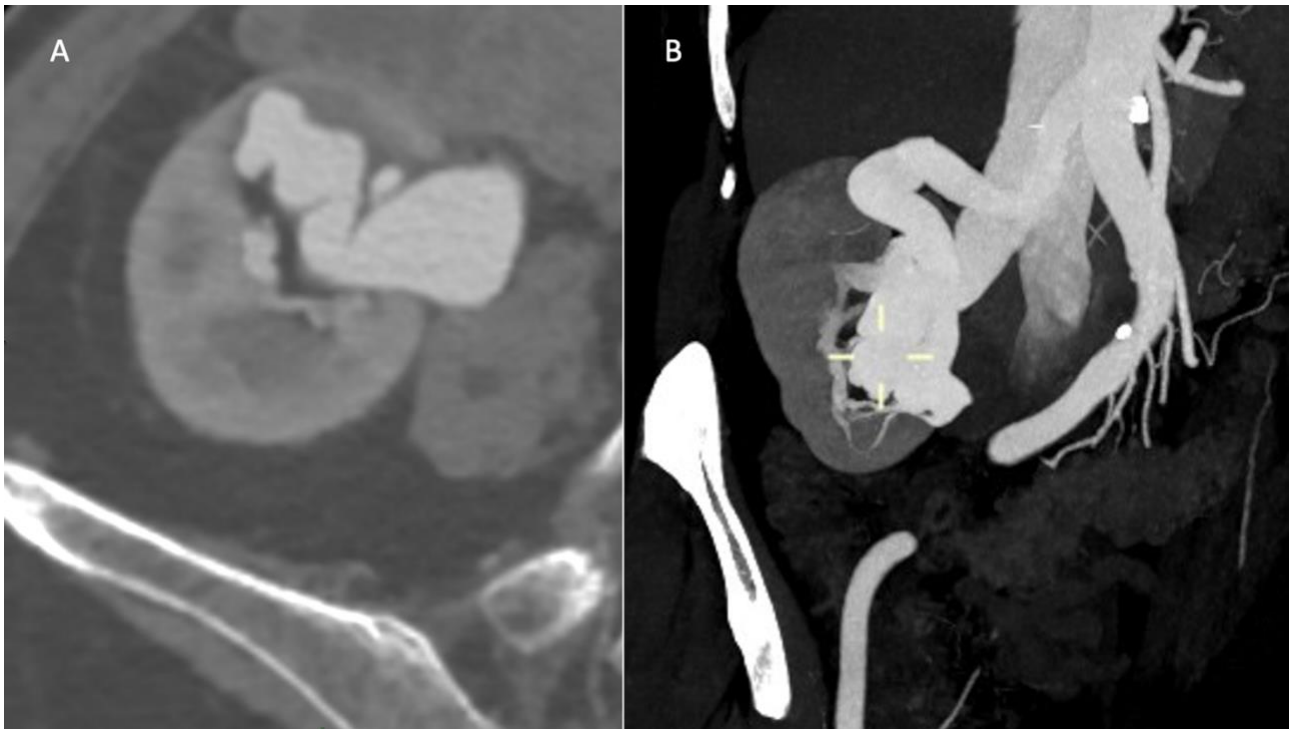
3D Volume-rendering of the Computed Tomography (CT) angiography showing the right renal arteriovenous malformations.
